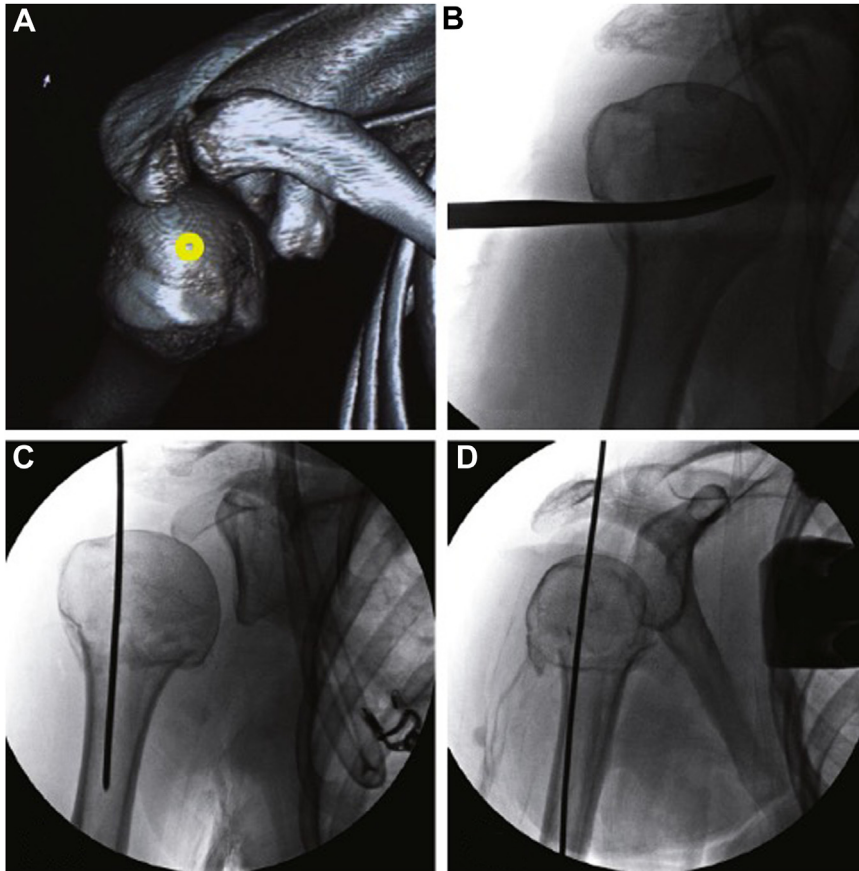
Radiographic depiction of the rotator cuff split entry point for humeral nailing; a commonly used approach. Note: This approach sacrifices the articular surface with a longitudinal incision through the rotator cuff, but with the benefit of easy access especially with arm extension.
